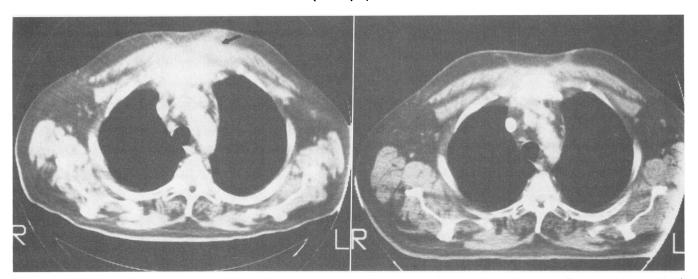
Chest computed tomography in patient 1 shows, left, sternal destruction and inflammatory response extending through bone and soft tissue to the chest wall surface (arrow). Right, 9 months later, after surgical debridement and antibiotic therapy, the destructive process of the sternum is nearly absent.
